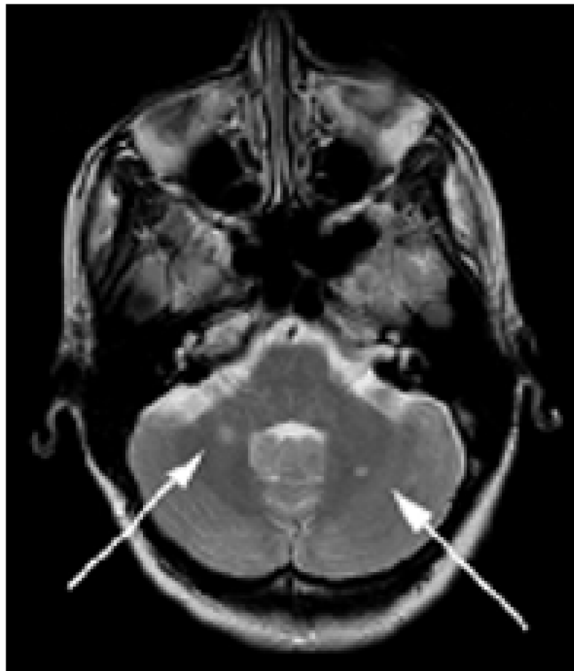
Brain MRI showing two MS lesions (white arrows) in the cerebellar white matter
